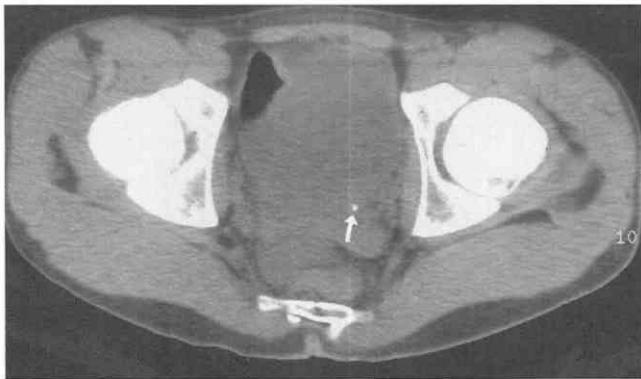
Non-contrast renal CT protocol. Axial image demonstrates a 2- to 3-mm calculus in the ureterovesicular junction (arrow) in a patient with left flank pain and hematuria.
